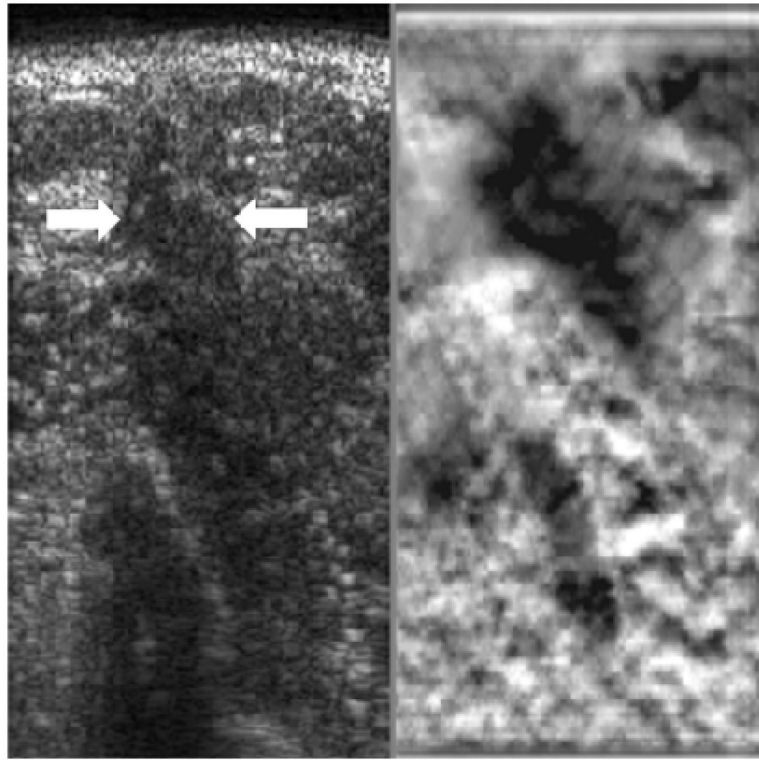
Sonogram (left side image) and elastogram (right side image) of an invasive ductal carcinoma showing a stiff lesion (dark) on the elastogram that is somewhat larger than the hypoechoic lesion seen on the sonogram (white arrows).
